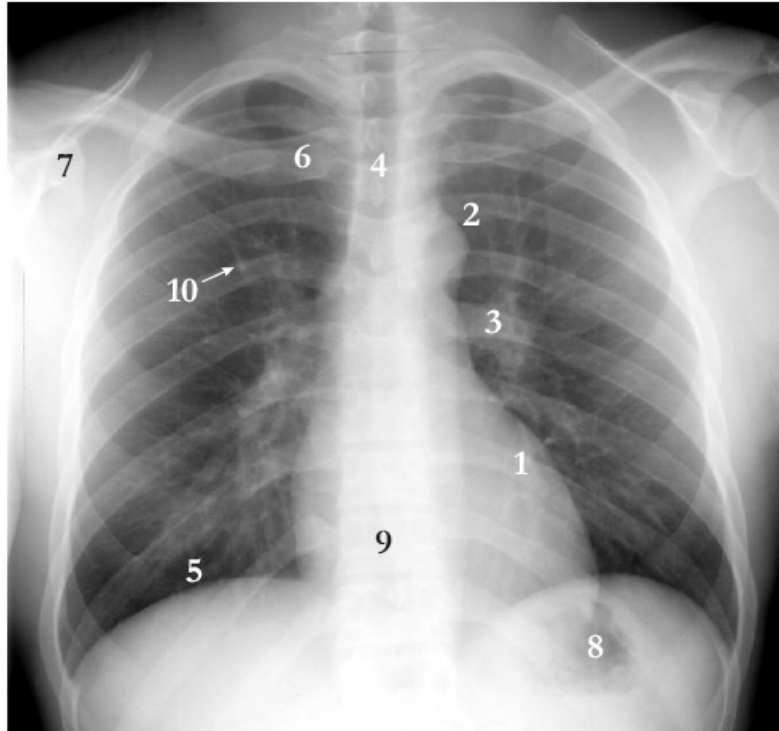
A normal posterior-anterior chest radiograph (this image was taken from [5]).
